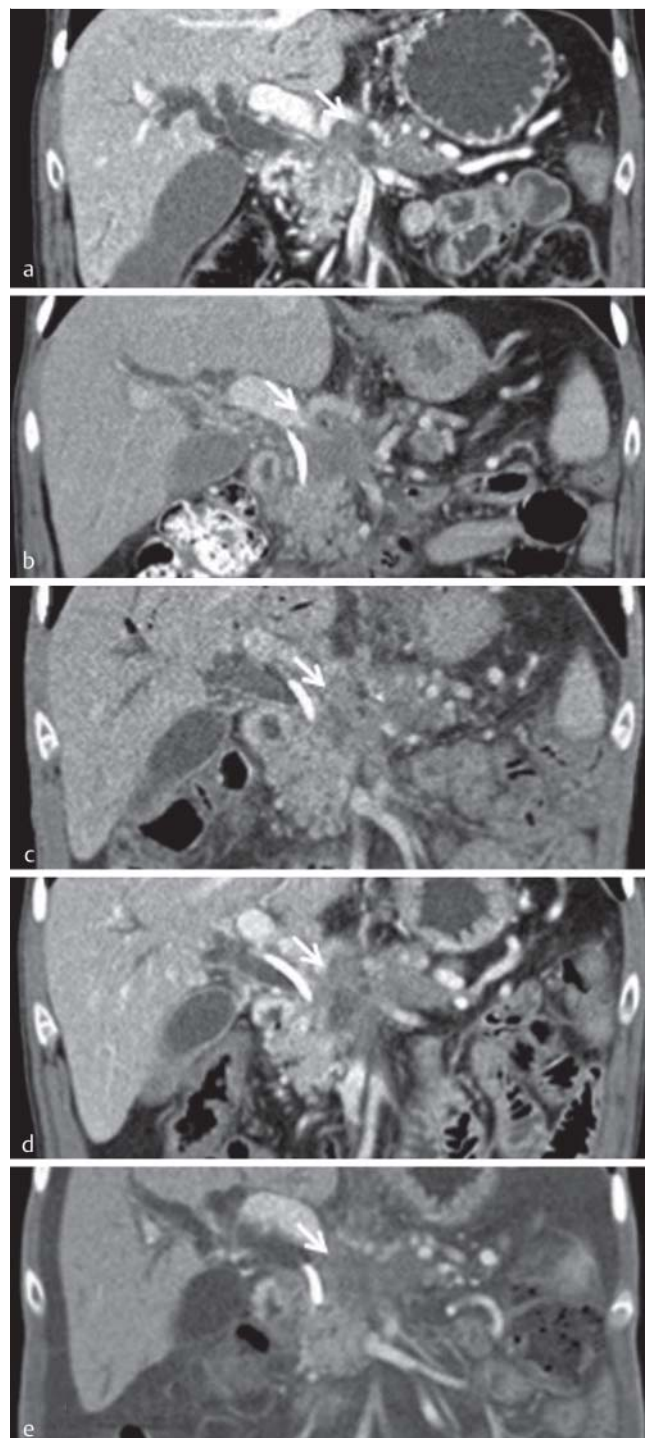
Patient with locally advanced pancreatic adenocarcinoma (LAPC) (arrow) rated as unresectable by visceral surgeons. The preprocedural CT scan a shows the LAPC in the head and body of the pancreas and consecutive intrahepatic cholestasis. Follow-up CT examinations one day b as well as one c, three d and five months e after IRE ablation using four electrodes show progressive shrinkage of the tumor with good local tumor control. The integrity of the nearby vessels is also confirmed by contrast-enhanced CT images.
